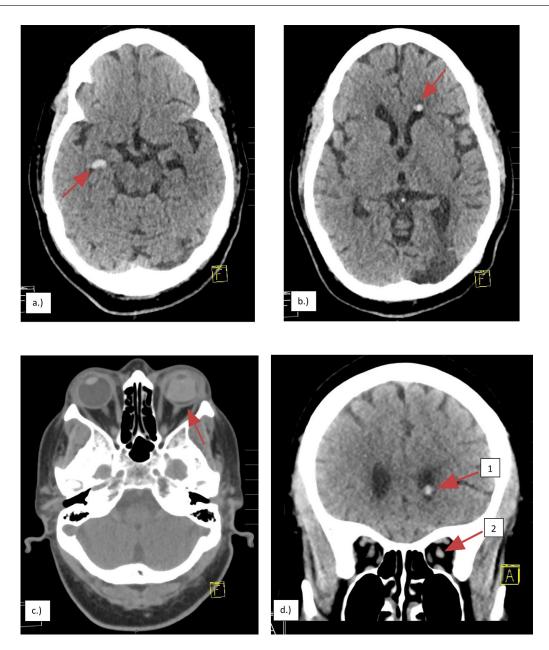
Axial non-contrast CT head demonstrating bilateral hyperattenuating foci within the non-dependent frontal horns, measuring 6.5 mm on the right (A) and 5.0 mm in diameter on the left (B, D-arrow 1), hyperdense silicone oil in the vitreous of the left globe (C), and migration of silicone oil into the left optic nerve sheath (D- arrow 2).
